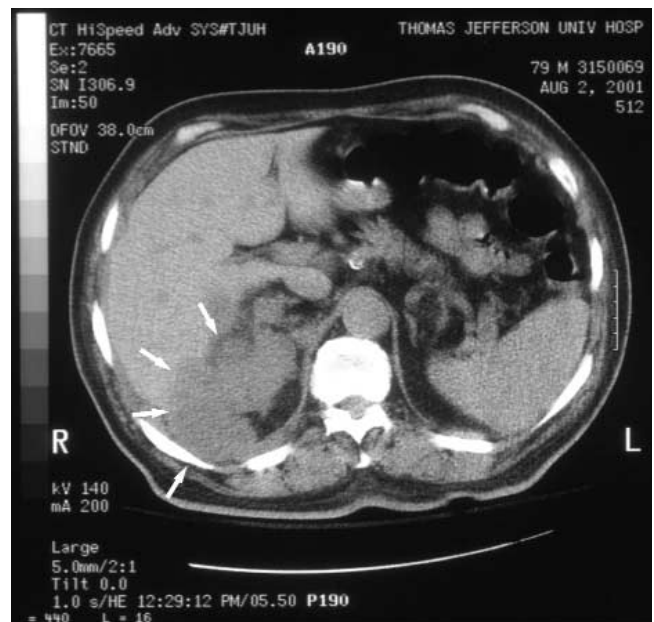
CT Thorax without IV contrast. Note the large homogenous mass (arrows) in the right retroperitoneum involving the adrenal and kidney. It extends into the right pleural space.
